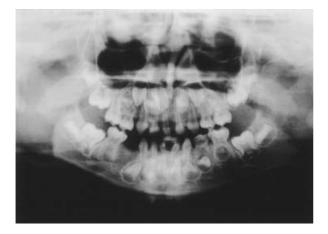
Radiograph taken at 7 years old showing congenital absence of 15, 21, 61, 25, 31, 71, 84, 44 and 45.
